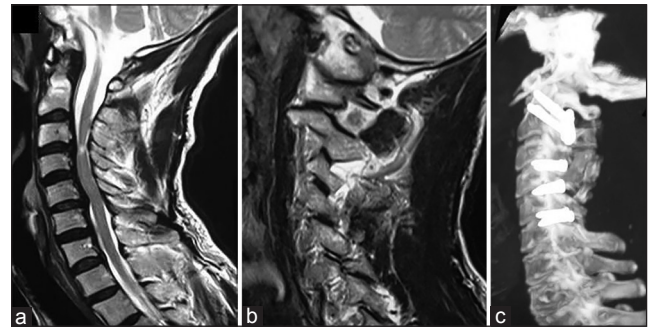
Images of a 52-year-old male patient. (a) T2-weighted MRI shows multilevel cervical spondylosis. (b) MRI slice through the facets showing posterior atlantoaxial dislocation. (c) CT reconstruction image showing the implants in atlantoaxial and subaxial regions
